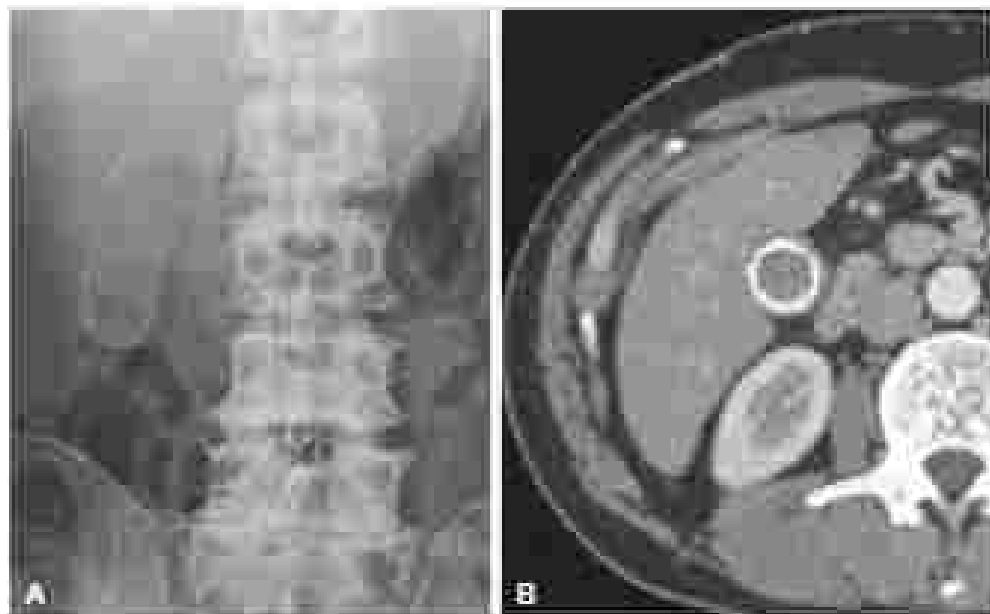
(A) Longitudinal view of the gallbladder wall showing extensive calcification. (B) Cross-sectional CT scan of the abdomen showing a gallbladder with a thick, bright white, calcified wall.
